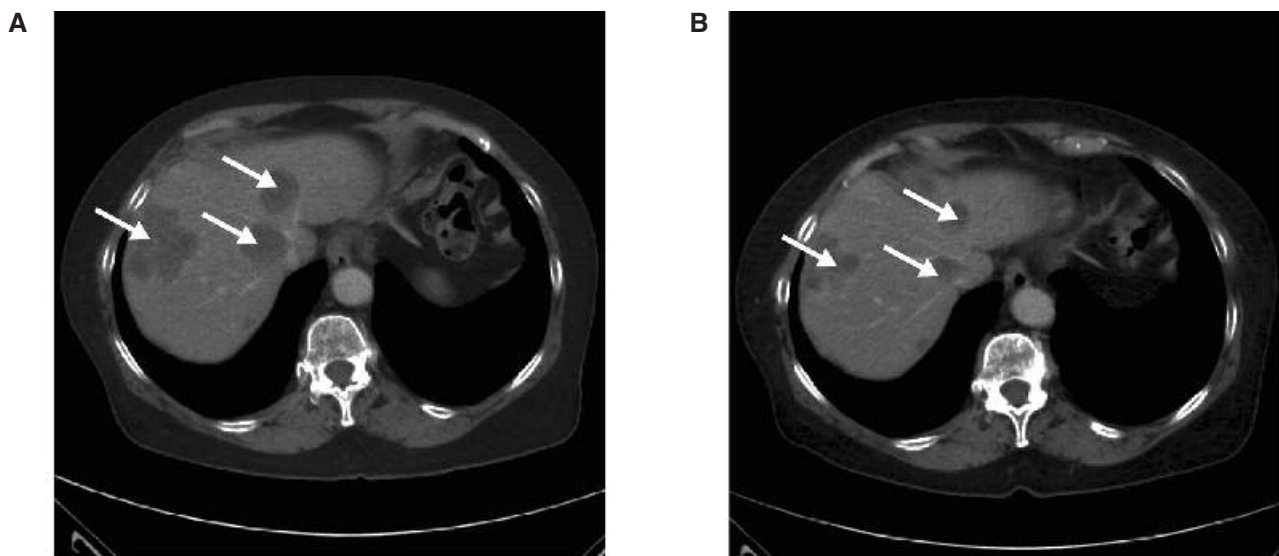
Computed tomography scans of the patient's liver (A) before and (B) after 2 months of panitumumab therapy, showing response to treatment.
